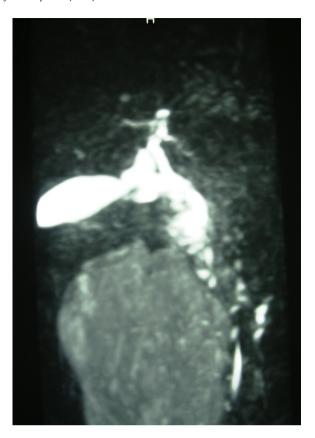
Abdominal MRI–MRCP demonstrating no filling or dilatation of the common hepatic, cystic, common bile and pancreatic duct.
